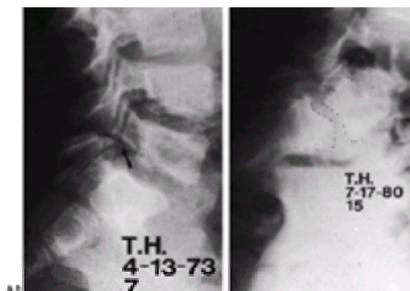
A: This 7-year-old boy was seen for lordosis. He was completely asymptomatic, and the radiograph showed a pars defect. He was treated with periodic observation. B: At 15 years of age, he was still asymptomatic, and was an outstanding high school athlete.
